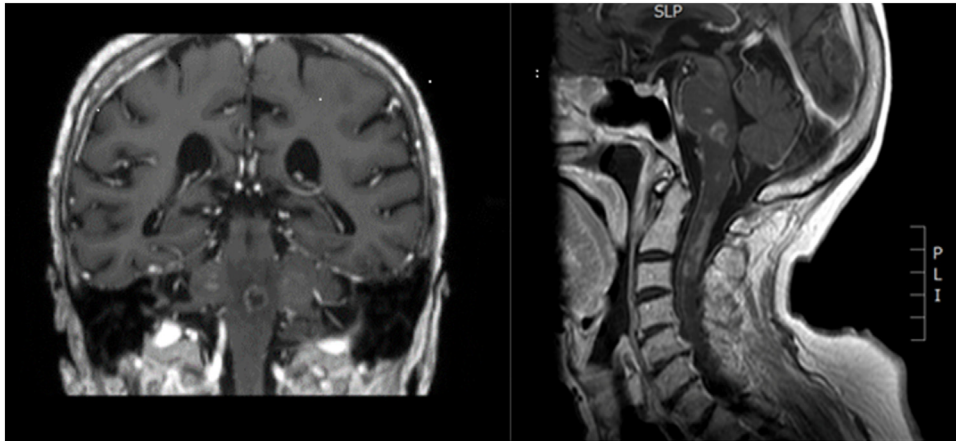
MRI showing contrast enhancing lesions in involving pons, medulla and cerebellum, suggestive for rhombencephalitis. Similar lesions are evident on the proximal tract of the cervical spinal cord.
